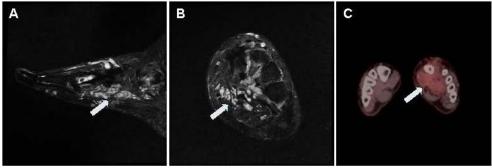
Radiographic evidence of PHTS-associated arteriovenous malformations of the left foot. Sagittal (A) and axial (B) cross-sections of MRI of the left foot demonstrate a large nidus of vessels (white arrows) in the deep flexor compartment of the medial two-thirds of the foot with numerous small radiating tributary vessels extending superficially, most consistent with a cavernovenous malformation. (C) Axial cross-section of FDG PET/CT through the mid-foot reveals mild FDG uptake in a poorly defined soft tissue density of the left plantar region (white arrow), likely related to the left foot vascular malformation following sclerotherapy treatments.
